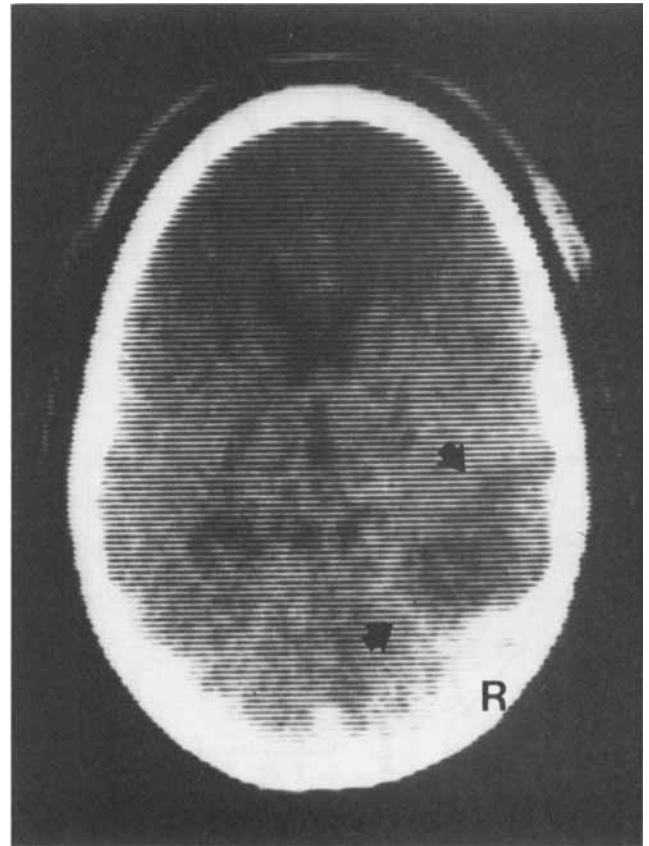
Case 2. CT scan showing low density abnormality with surrounding contrast enhancement (arrows) in the right posterior temporal region. The findings are those of acute thrombotic infarction.
